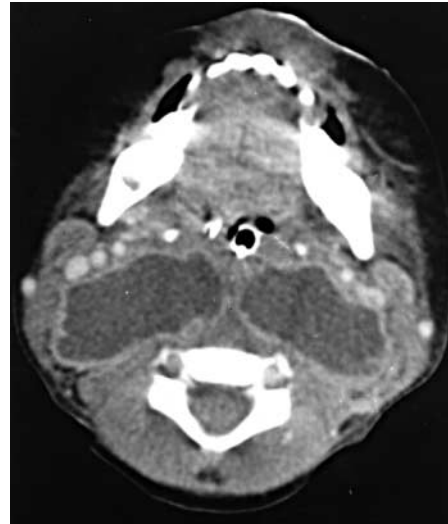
Axial computed tomographic scan of neck showing a massive symmetrical retropharyngeal abscess
